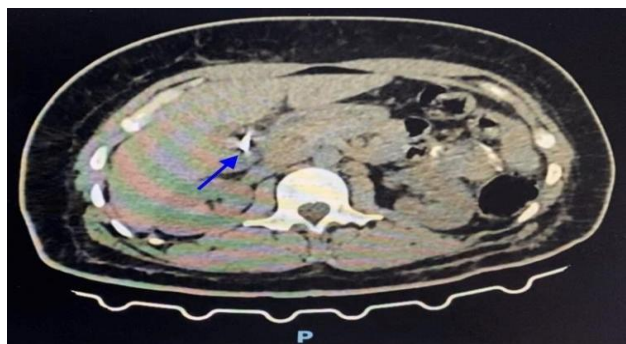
CT scan of the abdomen shows a small amount of liquid collected on the hepatic bed, extending medially adjacent to the VI hepatic segment (marked by the blue arrow).
